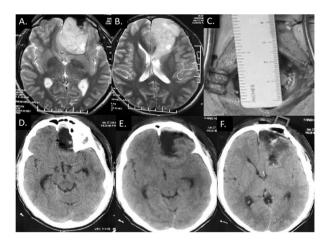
A & B shows the T2 weighted MRI with a large left parafalcine mass arising from the ventricle approached with awake minicraniotomy. C shows the 3cm sized bone opening.
